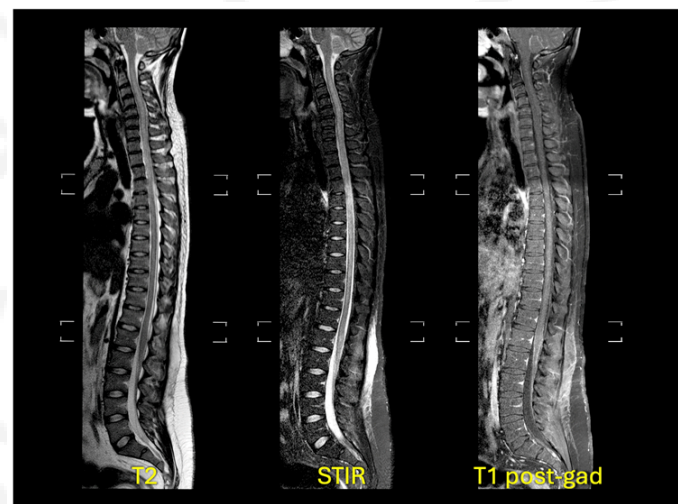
Sagittal view of spine and neuroaxis MRI showing extensive hipermedullary signal and leptomeningeal enhancement.
